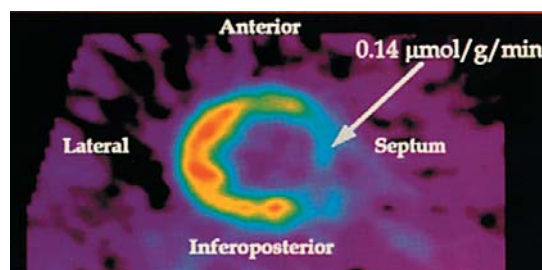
FDG scan from a patient with nonviable scar tissue.
